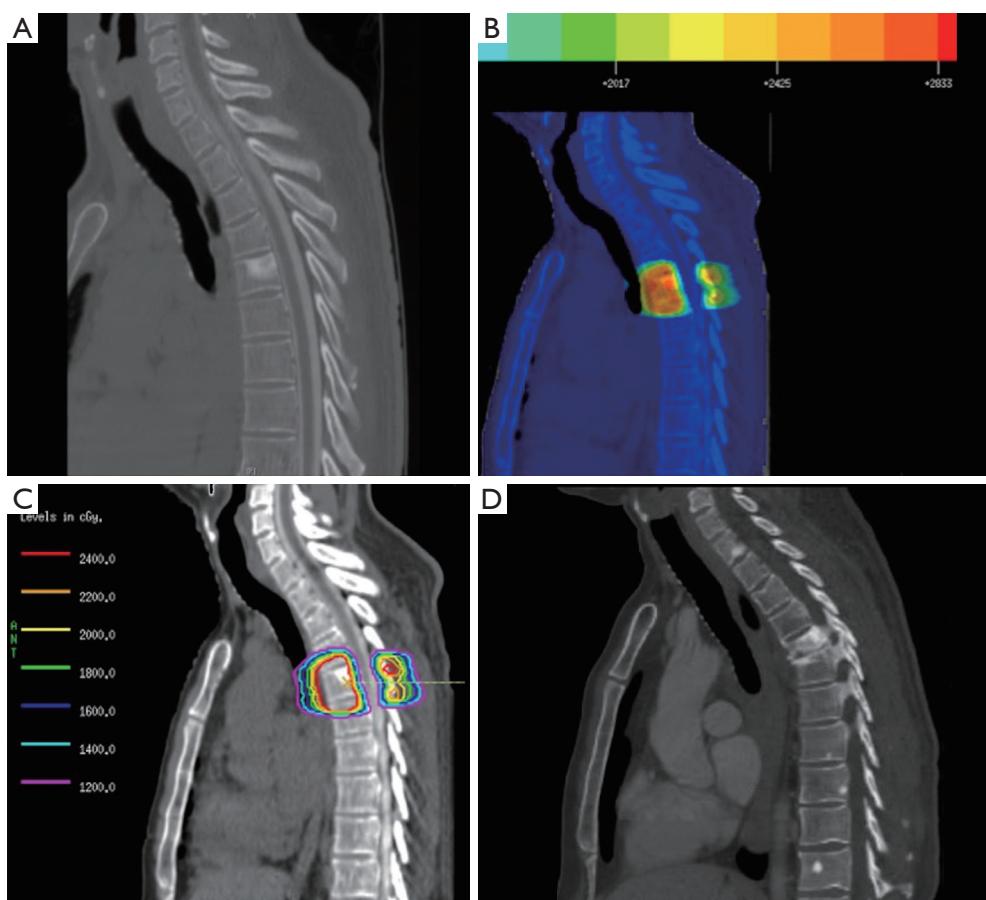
(A) Pre-SRS sagittal CT of the spine demonstrating metastasis at T5; (B) SRS plan demonstrating dose to each area in dose color wash and (C) isodose lines; (D) post SRS adjacent level fracture at the adjacent endplate (superior endplate) of T6. SRS, stereotactic radiosurgery.
